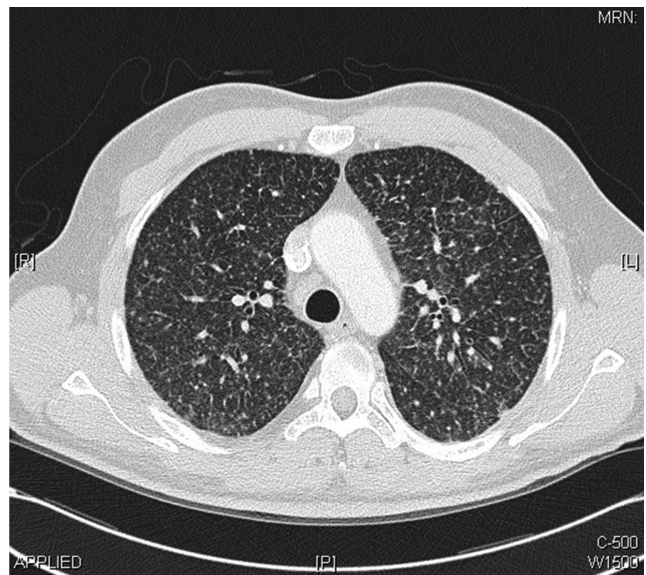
Chest CT scans performed within the first week of admission demonstrating bilateral miliary nodules of random distribution with bilateral hilar, subcarinal, paratracheal and prevascular lymphadenopathy.
